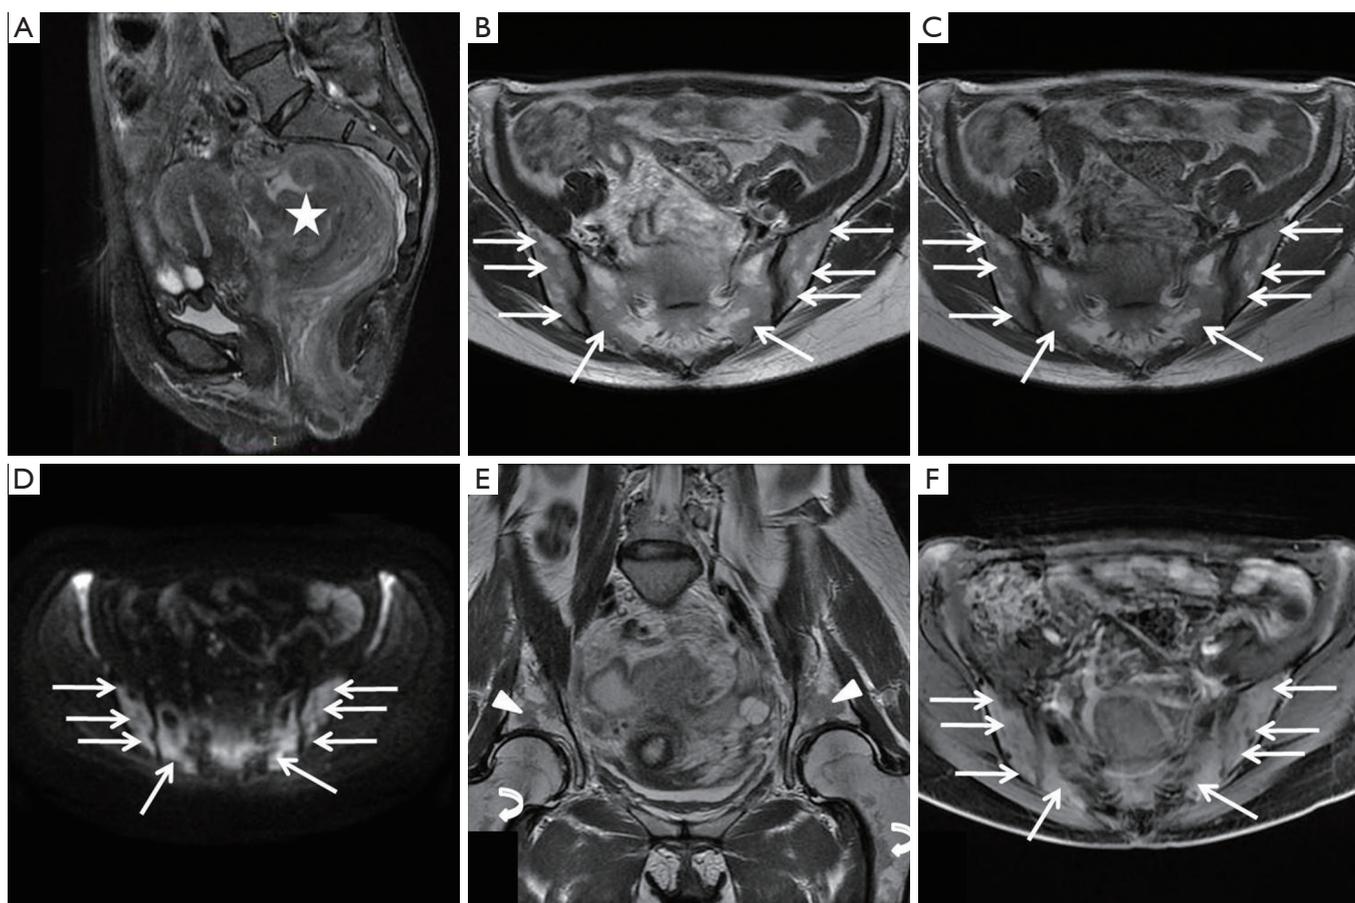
Pelvic MR images for a 45-year-old female patient with rectal cancer. (A) Sagittal T2-weighted MR image with fat saturation reveals a large primary tumour with slight heterogeneous hypointensity in the upper rectum (star); (B) axial T1-weighted MR image reveals diffuse multiple hypointensity lesions in the sacrum bone and bilateral ilium bone (arrows); (C) axial T2-weighted MR image reveals diffuse multiple hypointensity lesions in the sacrum bone and bilateral ilium bone (arrows); (D) axial diffusion-weighted MR image reveals diffuse hyperintensity lesions in the sacrum and bilateral ilia (arrows); (E) coronal T2-weighted MR image reveals multiple patchy hypointensity lesions in the bilateral iliac fossa bone (arrowheads) and upper femur (curved arrow); (F) axial contrast T1-weighted MR image reveals the lesions in the T1-weighted and T2-weighted images diffuse being enhanced in the sacrum bone and bilateral ilia (arrows).
